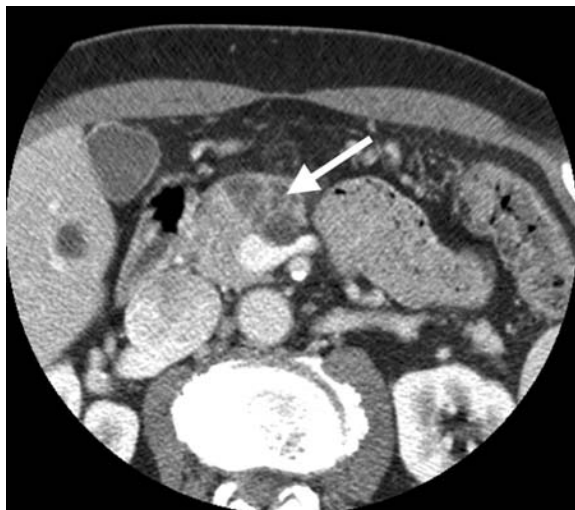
Computed tomogram showing a serous cyst. The mass lesion in the head of the pancreas consists of multiple small cystic lesions (*arrow*). The findings are typical of serous cystadenoma.
